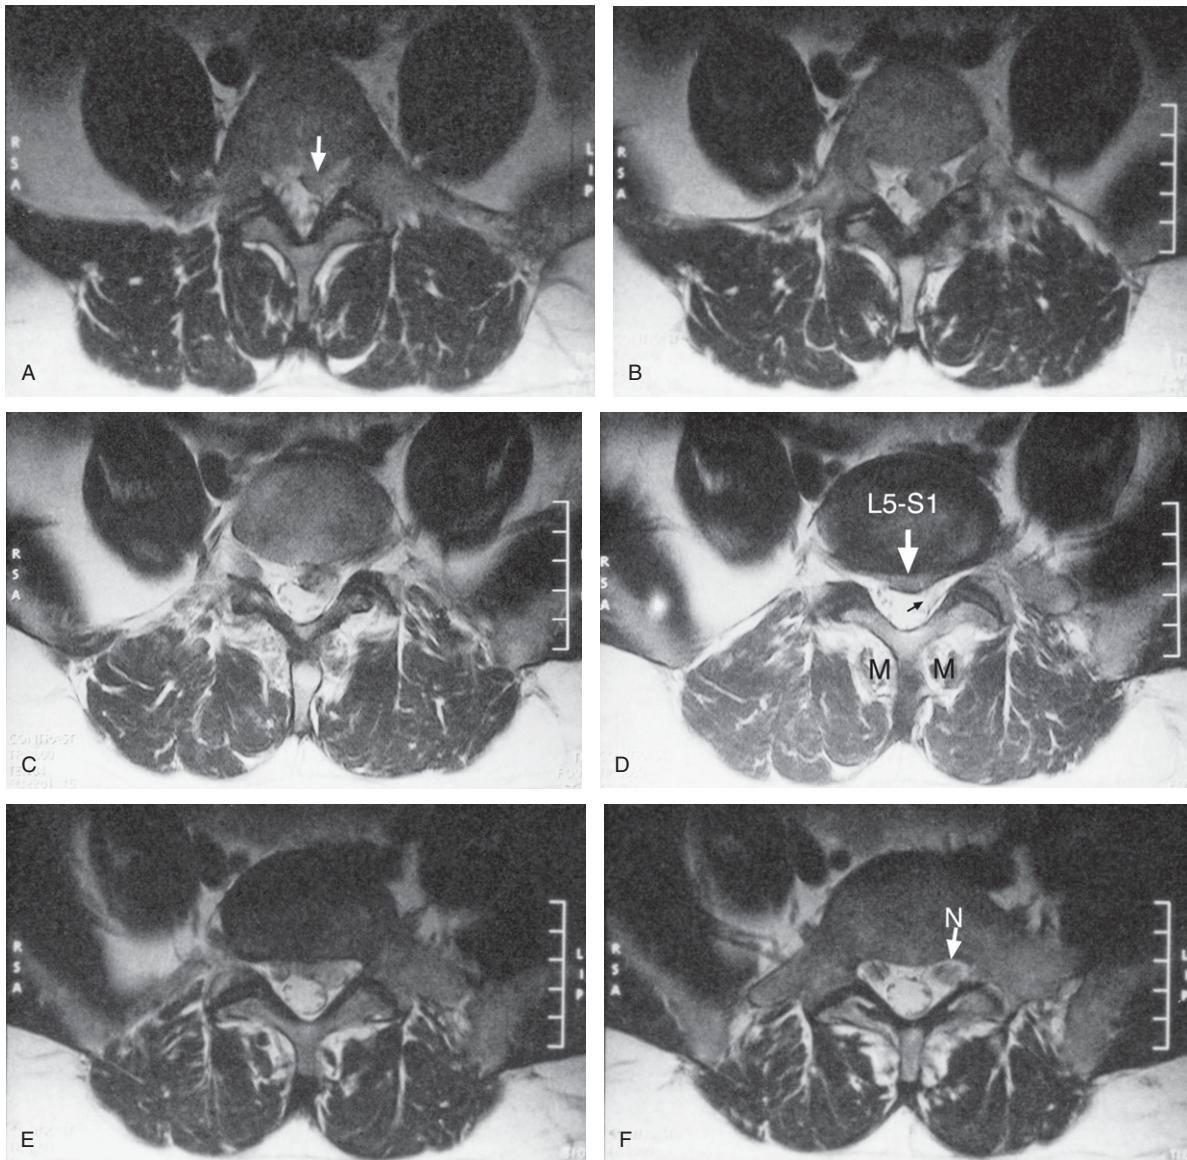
A series of MRI axial T2-weighted images showing the top of the probable epidural haematoma (arrow) in A and lower images showing it in B and C. The L5-S1 central to left paracentral posterior intervertebral disc protrusion (white arrow) that presses upon the dural tube anteriorly is close to the forming left S1 nerve root (small black arrow in D). Note the normal spinal canal seen in F with normal nerve roots (N). Early atrophy of the multifidus muscles (M) is seen.
